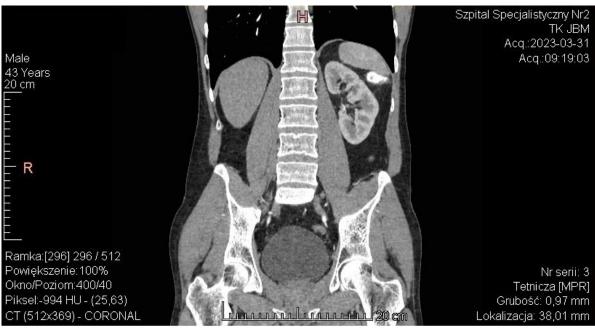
Image reconstruction from contrast-enhanced CT scan of abdomen and small pelvis in arterial phase. Absence of right kidney in its typical position.
